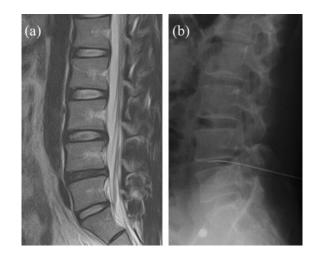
Representative radiological images. (a) MRI of a degenerative disc, limited to a single level. (b) After positive discography findings, performed using a contrast agent, intradiscal injection was performed under fluoroscopic guidance.
